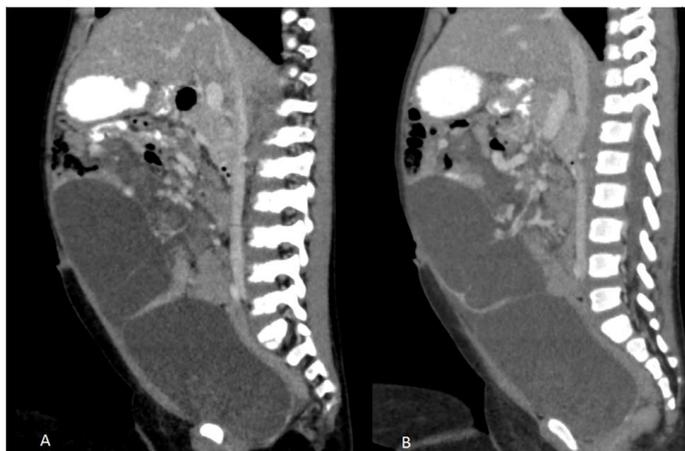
(A-D)- Axial Contrast enhanced CT abdomen showing multilocular cyst in mesentery in umbilical region showing counterclockwise barber pole sign distal to root of mesentery (A-B) and enhancing mesenteric vessels in septations (C-D)
